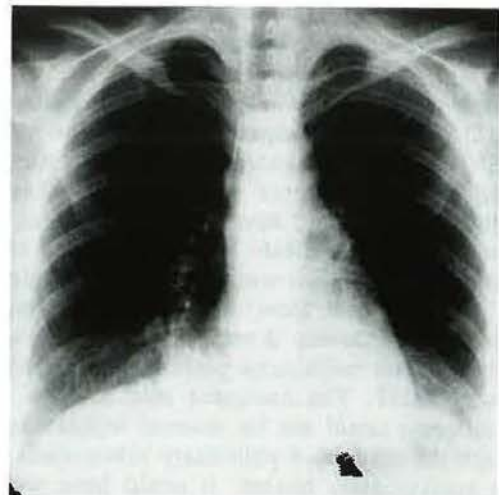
Chest X-ray taken 8 h after the accident shows infiltration in right middle and left lower lobes (patient 1).
